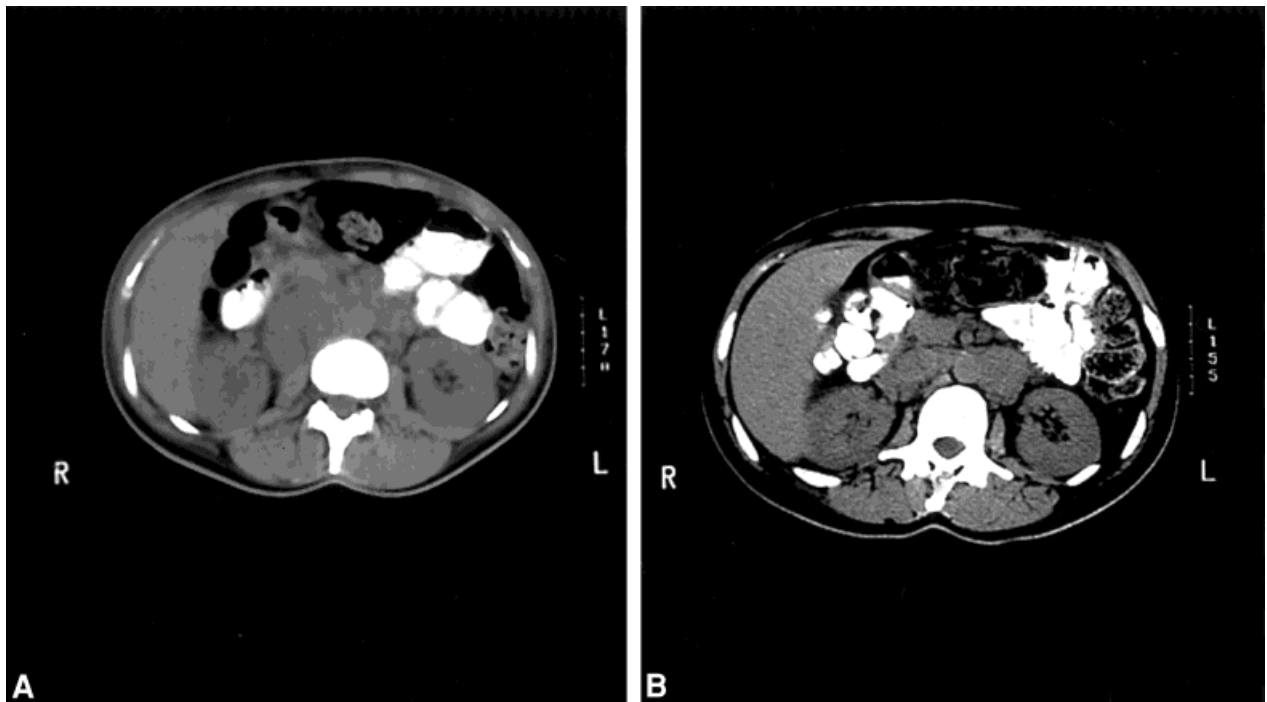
A partial response for Patient 2 is represented. (A) Before: Computed tomography (CT) shows intraabdominal adenopathy prior to the start of chemotherapy. (B) After: CT following four cycles of paclitaxel and tamoxifen shows a decrease in the patient's adenopathy.
